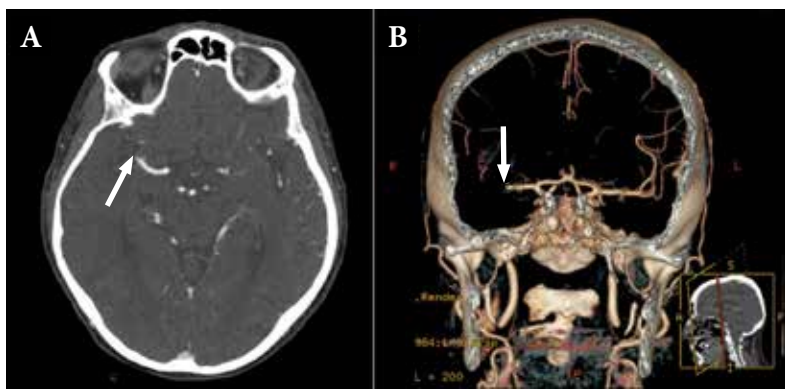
Brain CTA showing a right M1 segment MCA artery occlusion (Arrows). A) Axial CTA. B) Coronal 3D CTA reconstruction.
